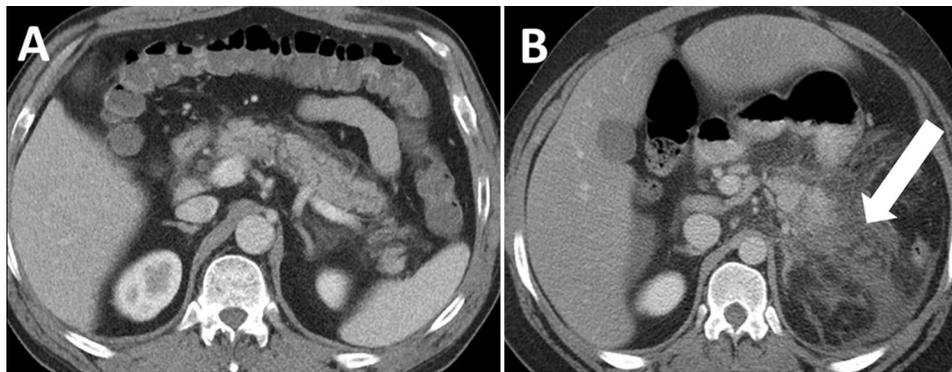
Interstitial edematous AP compared to necrotizing AP. a Intravenous contrast-enhanced CT (CECT) axial image in a 49-year-old man with ethanol induced acute pancreatitis with onset 2 days prior shows a diffusely edematous pancreas with peripancreatic stranding, consistent with interstitial edematous AP. b CECT axial image in a
